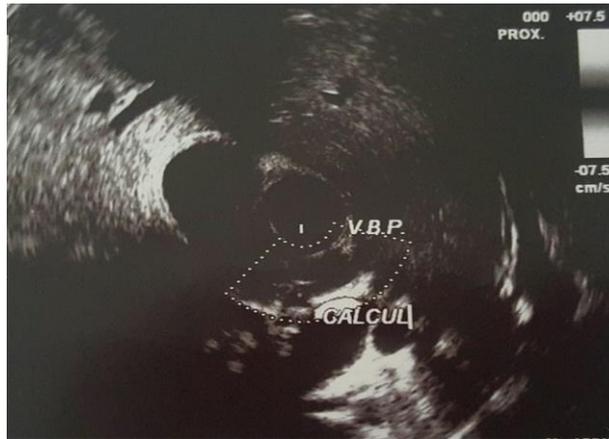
Endoscopic ultrasound view showing a calculation of the lower bile duct responsible for its dilation
